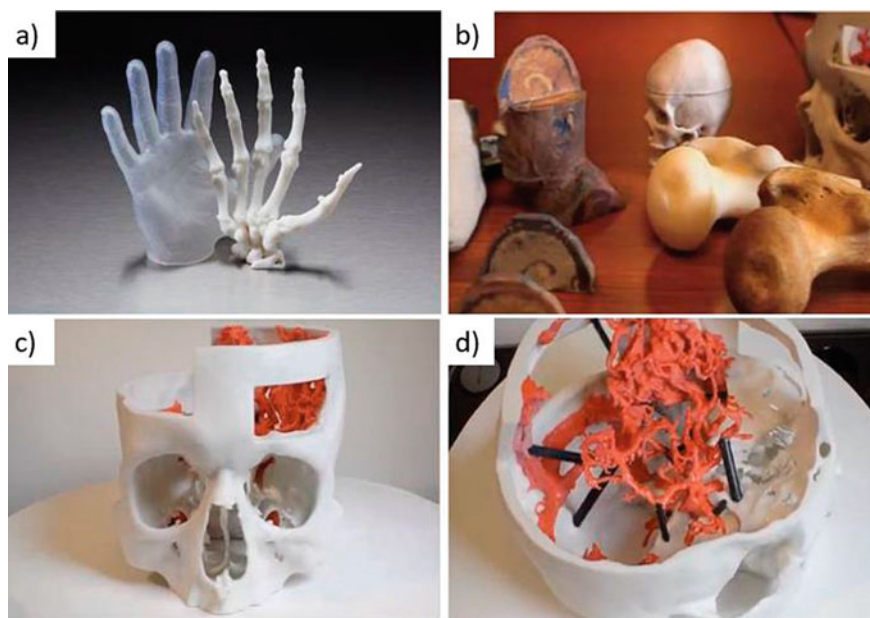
a. Anatomical model of a hand, including the 'skin' made out of an elastic 3D printing material. b. Researchers at the National Library of Medicine generate digital files from clinical data, such as CT scans, that are used to make custom 3D-printed surgical and medical models. c. d. 3D model used for surgical planning by neurosurgeons at the Walter Reed National Military Medical Center. *Source* The Guardian (NIH 3D Printing Exchange)
